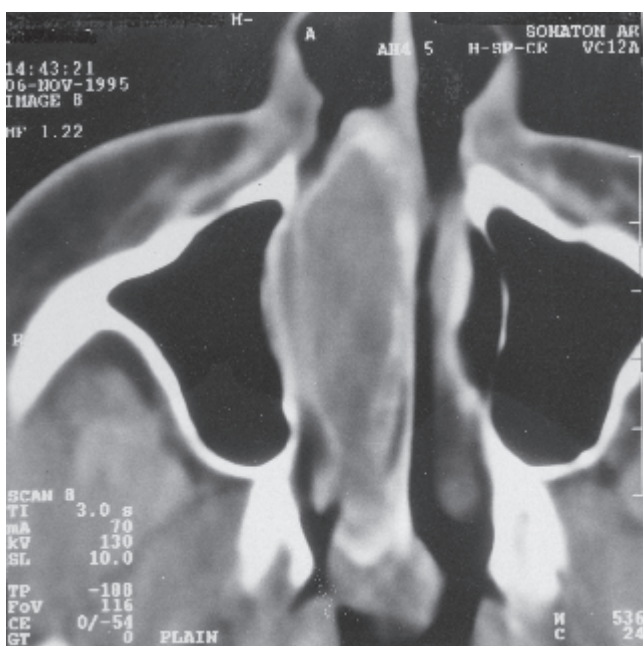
Axial CT showing a mass with a thin shell extending from the anterior nares to the postnasal space touching the Eustachian tubes.
